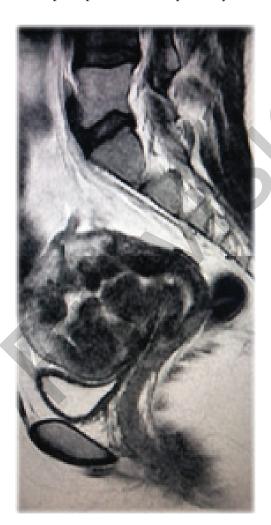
MRI showing multiple myomas with distorted endometrial cavity
